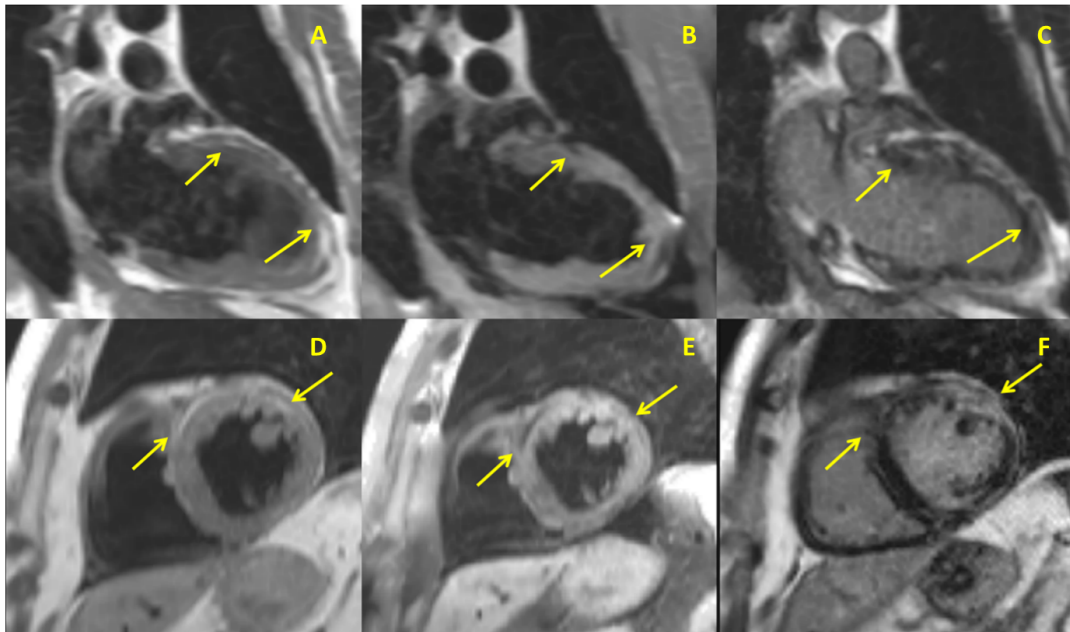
A representative cardiac MRI image from patient II:10 in Family 4. It shows 2 chambers and short-axis LV turbo spin echo images with and without fat saturation and late gadolinium enhancement image on the same slice of a AC patient positive for a mutation in *DSP*. Arrows indicate some areas of fat infiltration (A, B, D, E) and fibrosis (C, F).
